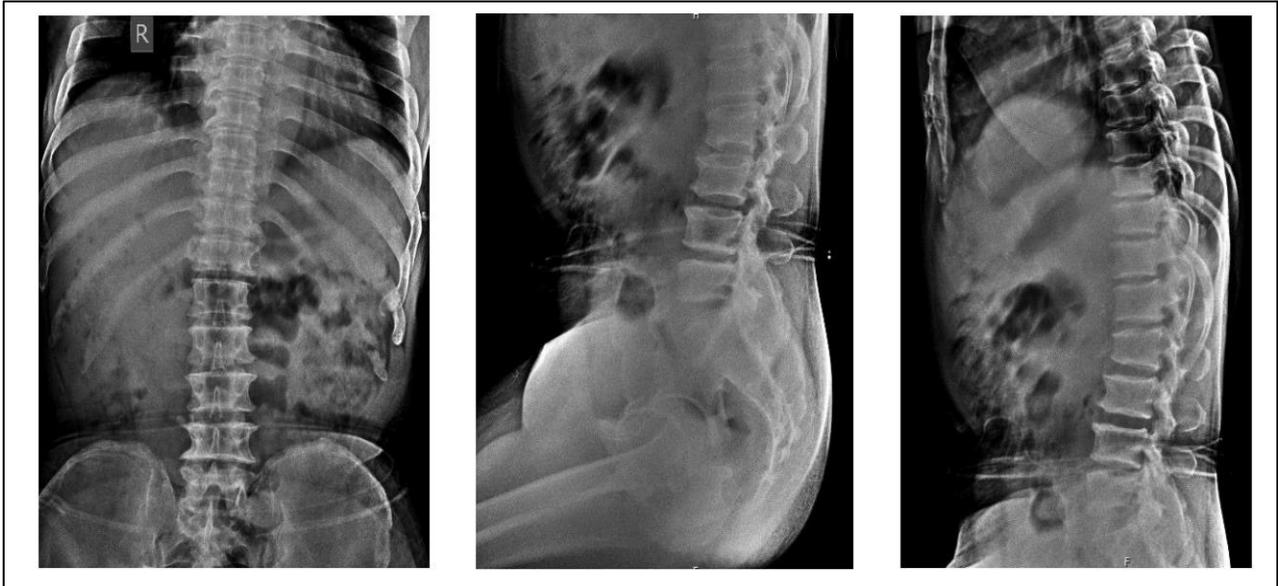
AP and Lateral Lumbar Spine Radiographs in a 44-Year-Old Male with HCH.
